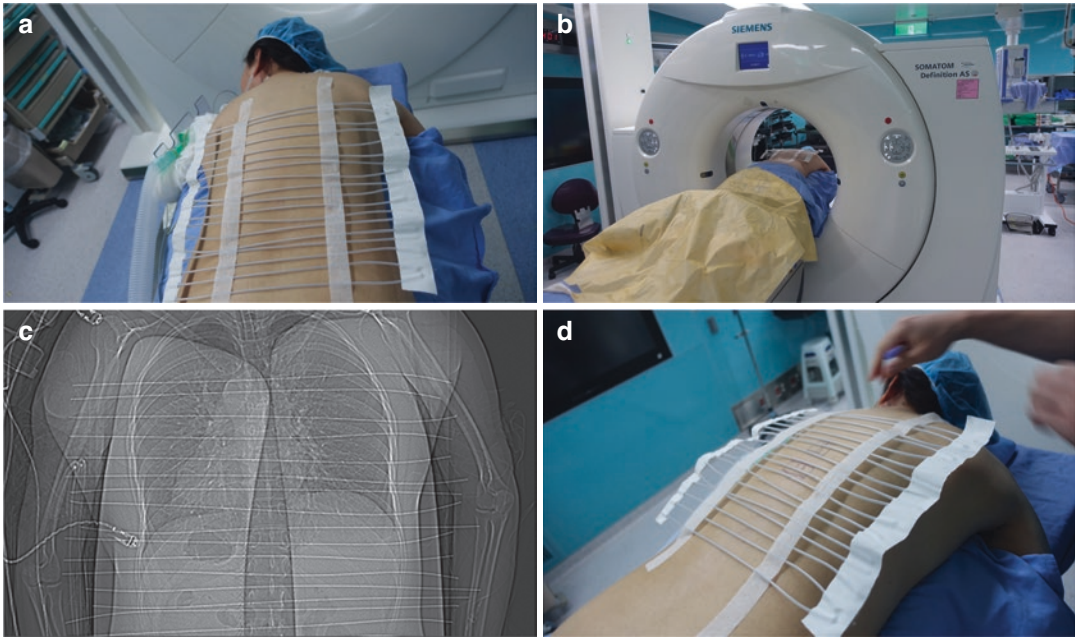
The CT scanography can help to localize index level with low-dose radiation. (a) The radio-opaque tubes were pasted on the skin. (b) Perform intraoperative CT
